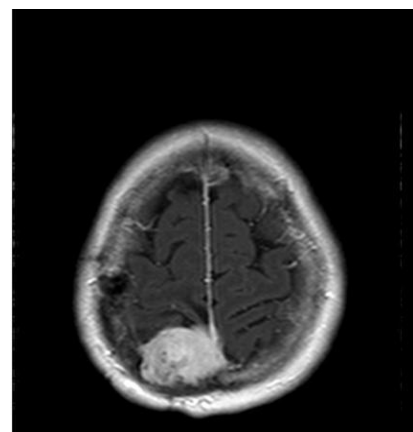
MRI parasagittal meningioma in the middle third
